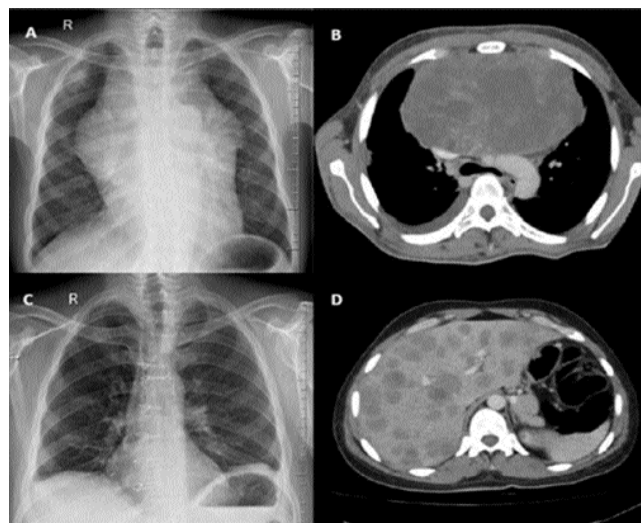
(A) Chest X-ray at baseline showing a huge mediastinal mass. (B) Baseline computed tomography (CT) scan of chest showing mediastinal mass and small right pleural effusion. (C) Chest X-ray after initial treatment and surgery showing normal mediastinal diameter and surgical clips in place. (D) CT scan at relapse: multiple hypodense metastatic lesions in hepatic parenchyma.
